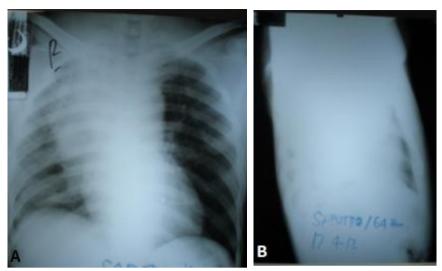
Chest X-Ray A. posteroanterior and B. lateral right position. A homogeneous opacity on the apex and the right para hiller with irregular borders, suggesting a right lung mass.
